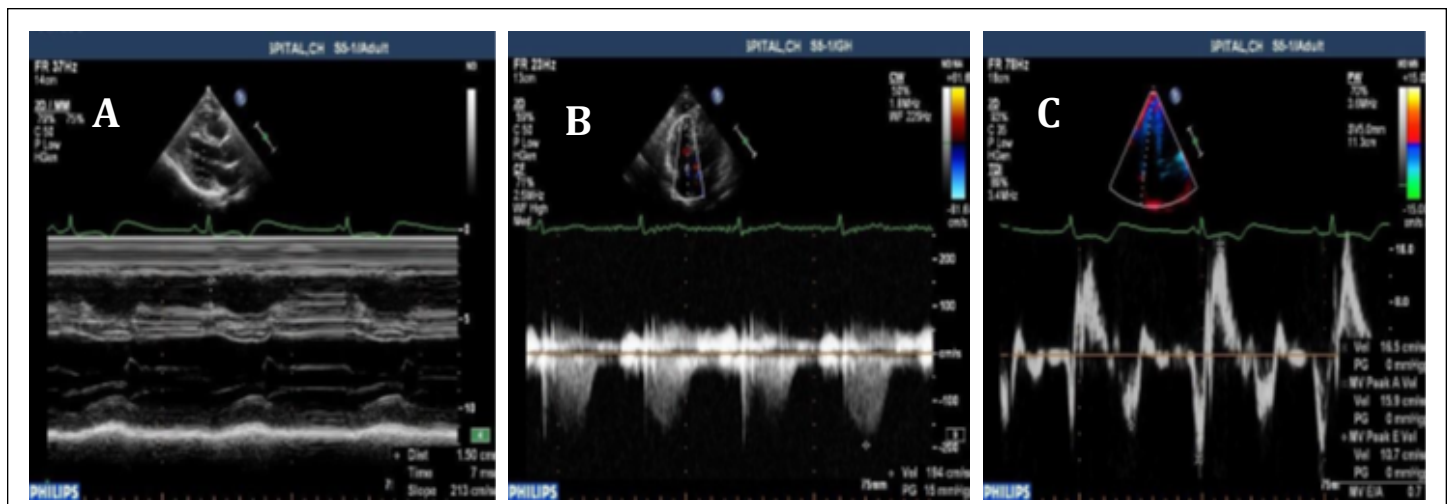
Tissue Doppler Imaging of RV.
